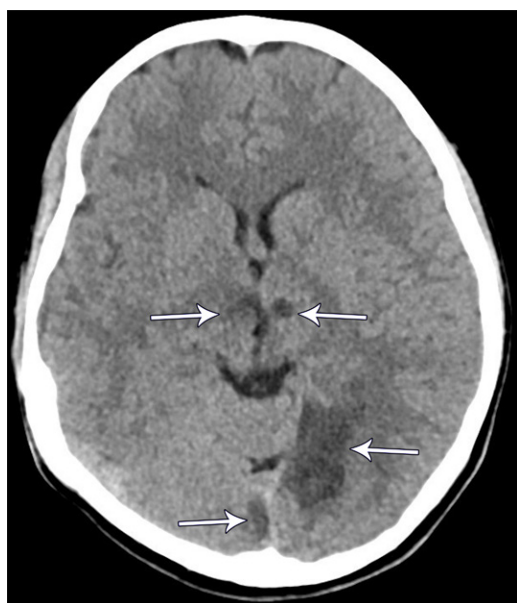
Multiple infarcts in a 12-year-old girl who presented with visual disturbance and numbness in the face and tongue. In VAD, established infarcts are often visible on the initial CT images due to nonspecific symptoms and delayed presentation. Axial noncontrast CT image shows areas of hypoattenuation (arrows) within both thalami and occipital lobes, consistent with subacute to chronic infarcts.
